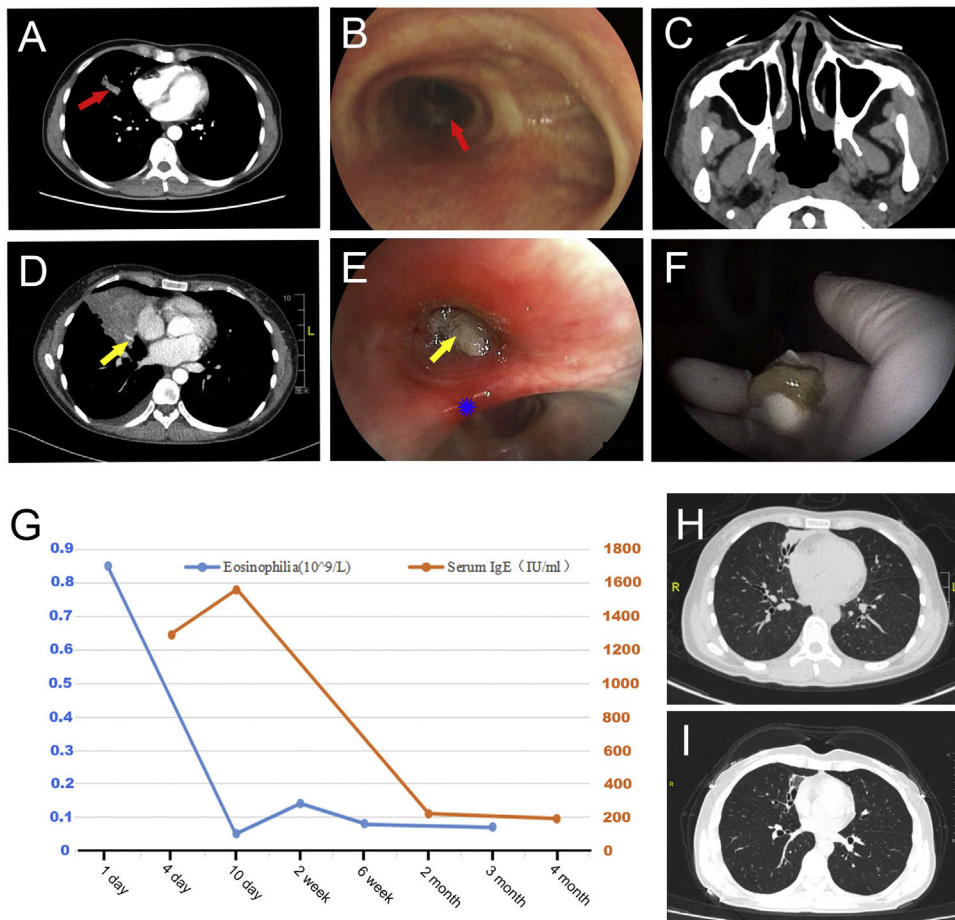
Chest imaging showed hyperattenuated mucoid impaction in the right middle lobe (A). Bronchoscopy showed chronic inflammation (B). Paranasal sinus CT image with negative result (C). Chest CT reexamination images showed the consolidation in the right middle lobe (D). Bronchoscopy showed a yellow mucous plugs, in the right middle lobe (E) and complete removed by cryotherapy under bronchoscopy (F). Eosinophils count and total serum IgE level (G). Chest CT 2 weeks after treatment with VRCZ (H). Chest CT 6 months after treatment with VRCZ (I).
